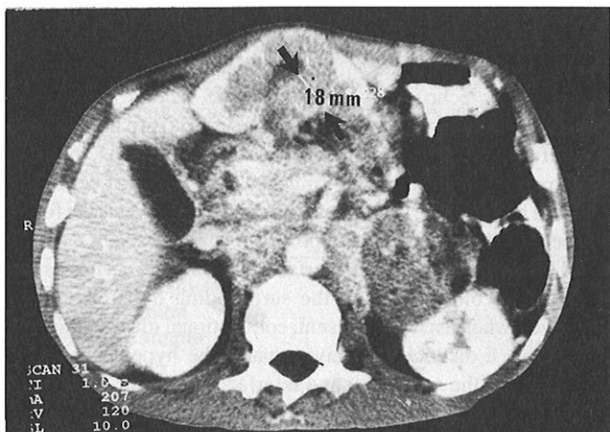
This is a CT scan of the patient in Fig 5. Note the anterior position of the gastric antrum that makes it readily accessible to conventional ultrasonography. The measurement of the posterior wall corresponds with the ultrasound findings. Note that the superior mesenteric vessels lie in the longitudinal plane of the gastric antrum.
